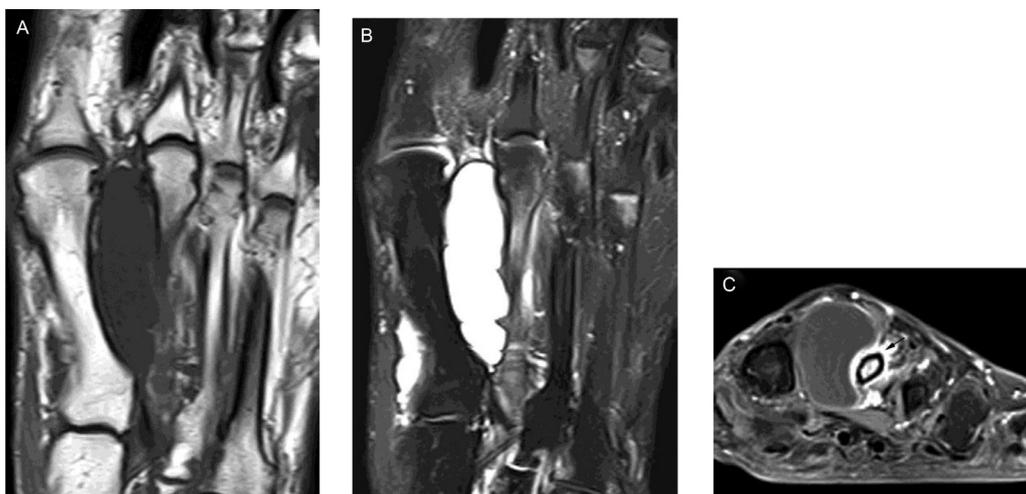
Ganglion cyst. (A) Axial long-axis T1WI demonstrates a well-defined, lobulated mass between the first and second metatarsals. (B) Axial long-axis fat saturated T2WI shows fluid signal. (C) Coronal short-axis fat saturated post-contrast T1WI shows a thin peripheral enhancement. The associated stress fracture in the second metatarsal shows prominent contrast enhancement (black arrow). T1WI, T1-weighted images; T2WI, T2-weighted images.
